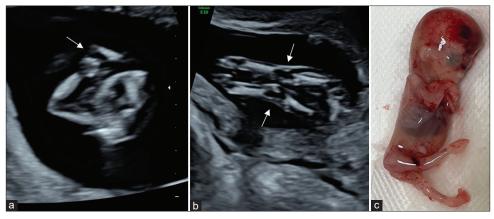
Fetal ultrasound performed at 11 weeks of gestation (a and b) and autopsy image of the 13-week fetus (c). (a) Fetal hands (arrow) fixed in front of the chest with a posture unchanged; (b) Fetal knees (arrow) were fixated and extended; (c) Upper limbs presented the same posture as *in utero*, and both knees were fixated in extension, with left club foot and right arthrogrypotic foot
